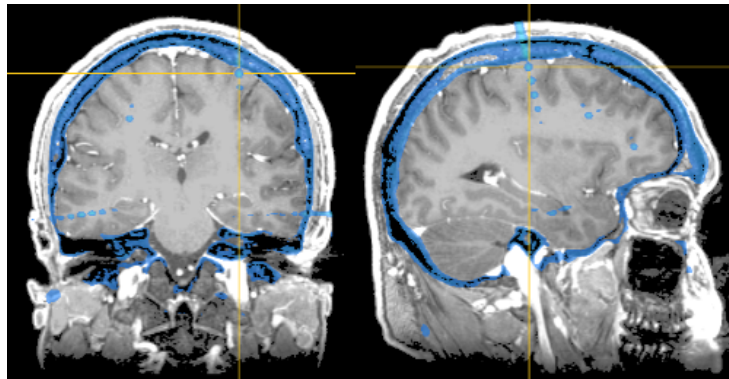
Starred channel RPI 10-9 electrodes localization in MRI image
